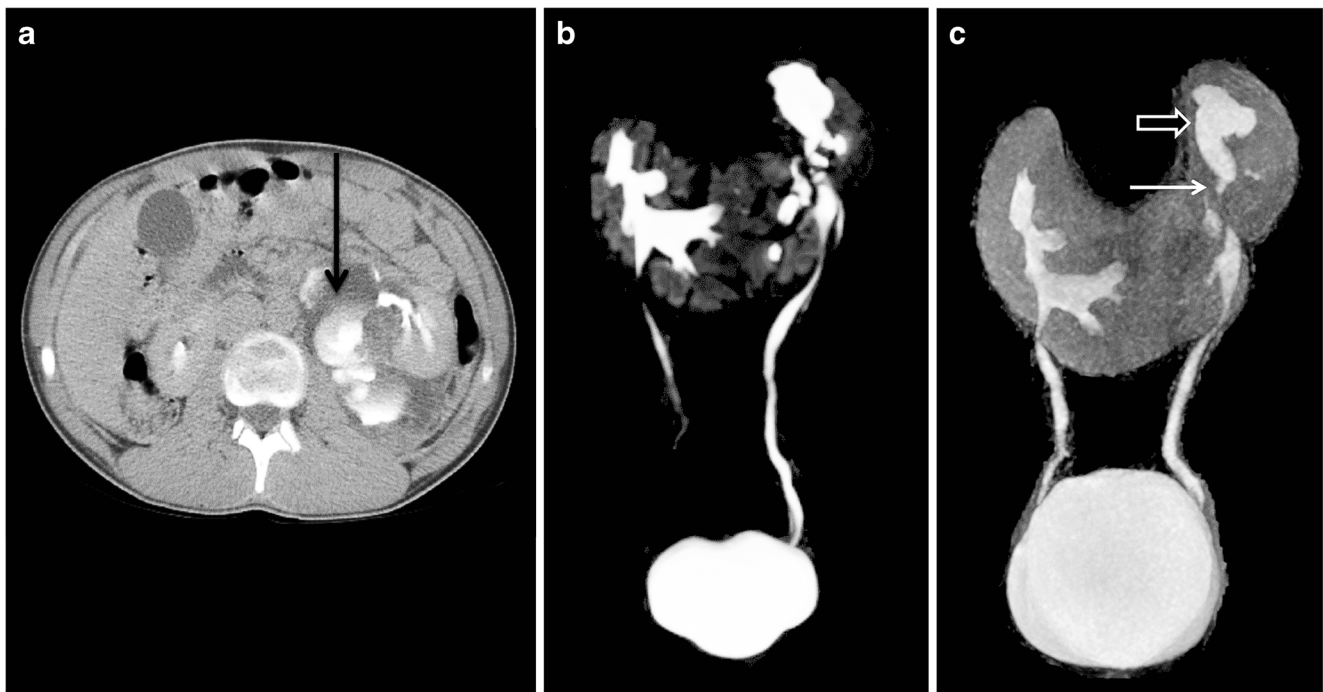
Horseshoe kidney in a 17-year-old boy who had abdominal pain months after he was involved in a motor vehicle accident. a Delayed axial CT at the time of injury shows contrast extravasation within the left perinephric space beyond the border of the left renal collecting system (arrow). b Several months later, the patient returned with increasing abdominal pain. Maximum intensity projection (MIP) reconstruction from an isotropic 3-D T2 fat-saturated sequence shows the left upper
